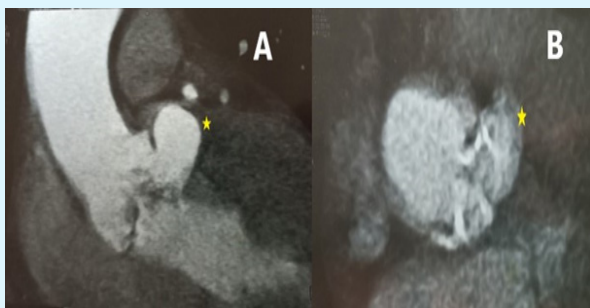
cardiac CT showing the pseudoaneurysm (Asterix) of the left coronary artery sinus of Valsalva in contact with the main left coronary artery.
